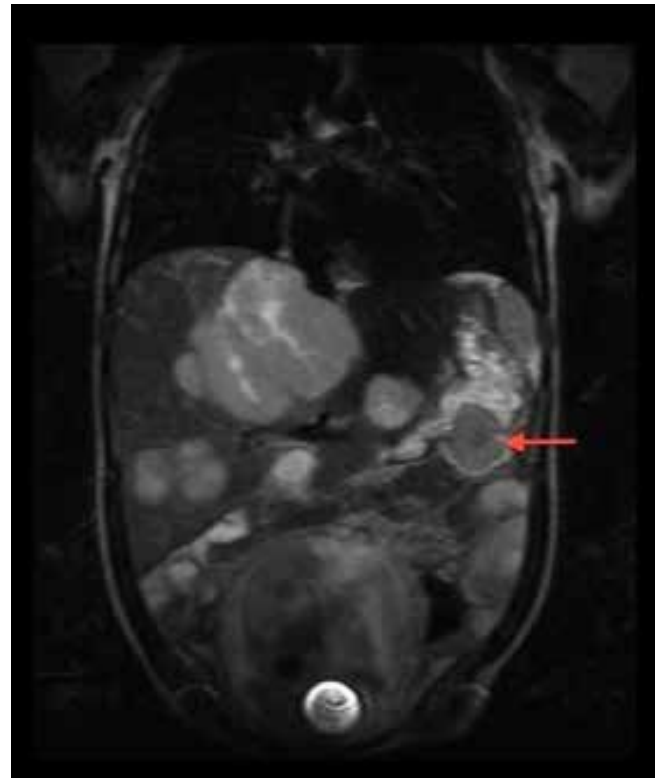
MRI of abdomen: Coronal T2 weighted sequence demonstrating an extra-hepatic lesion arising from the greater. A repeat MRI scan at 25 weeks gestation demonstrated rapid progression of the tumour within the stomach and liver. Subsequently, treatment with Imatinib was commenced.
